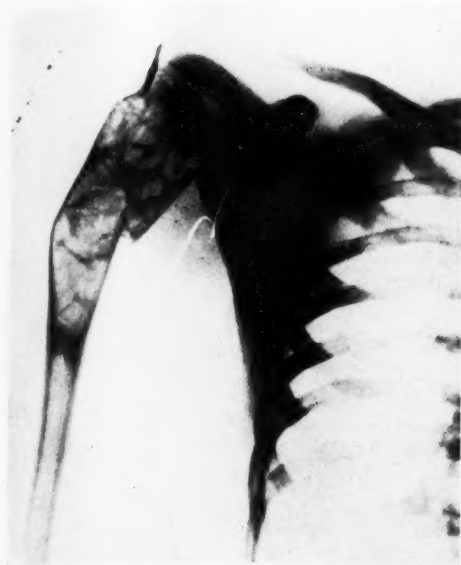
Benign bone cyst. Roentgenogram of a benign bone cyst situated in the metaphysis, with smooth symmetrical expansion, thinning of cortex, and pathologic fracture.
